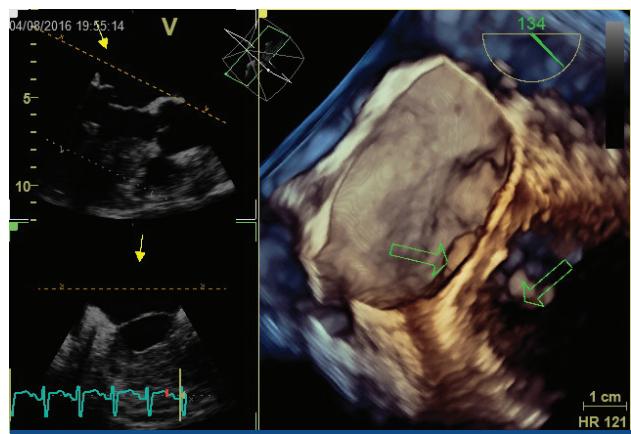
3D transesophageal echocardiogram. Arrows showing flail posterior leaflet in the left atrium and ruptured papillary muscle head in the left ventricle.
